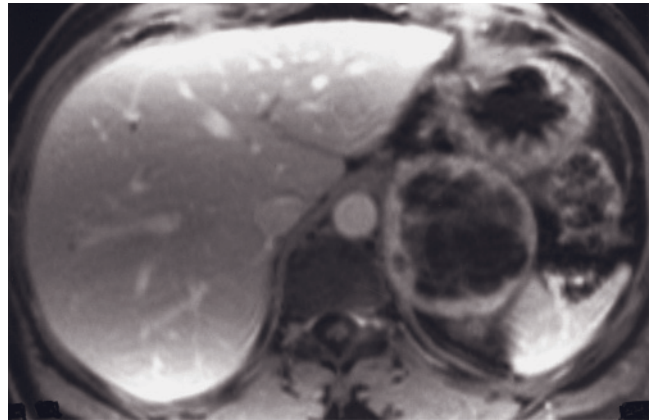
Large pheochromocytoma. T1-weighted GE (a), T1-weighted out-of-phase GE (b), T2-weighted echo-train spin-echo (c), immediate postgadolinium GE (d), and 90-s postgadolinium fat-suppressed GE (e) images. A 6-cm pheochromocytoma is present
